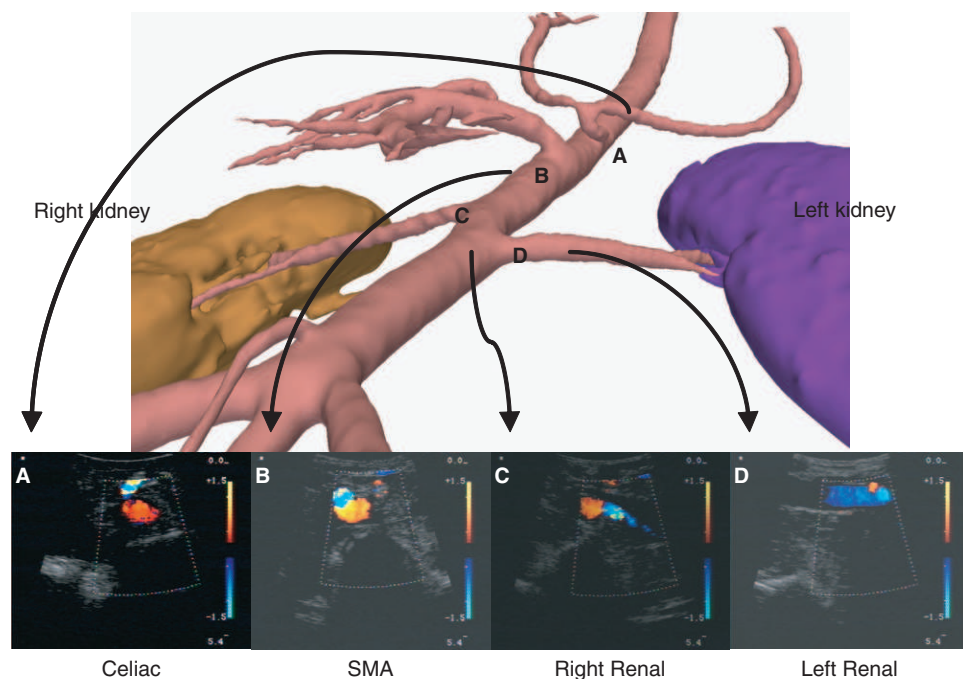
Landmark points chosen for system registration error validation and corresponding examples of the Doppler US views for each landmark point. The branching interface is coded in the Doppler US as a change of color due to a change in blood flow direction. [Color version available online.]
